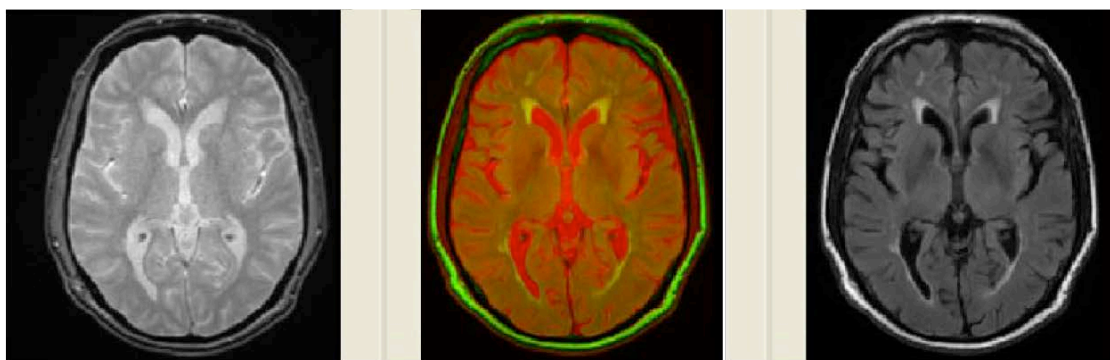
Shows a T2*W image fused with a FLAIR image in red-green (left-base, middle-fused, right-match).
